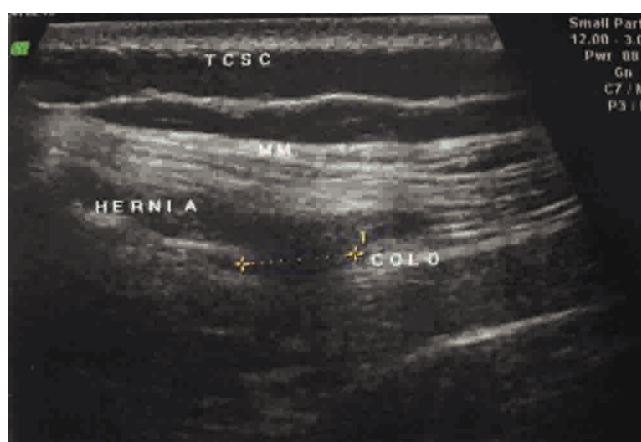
Sonography showing the muscle defect.
